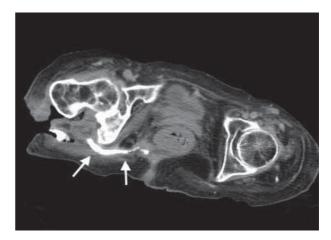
The CT scan showed a fistula between the right lateral posterior aspect of the anus and the open wound of right hip joint (arrows). The fistula located at subcutaneous and muscular layers with surrounding fatty infiltration.
